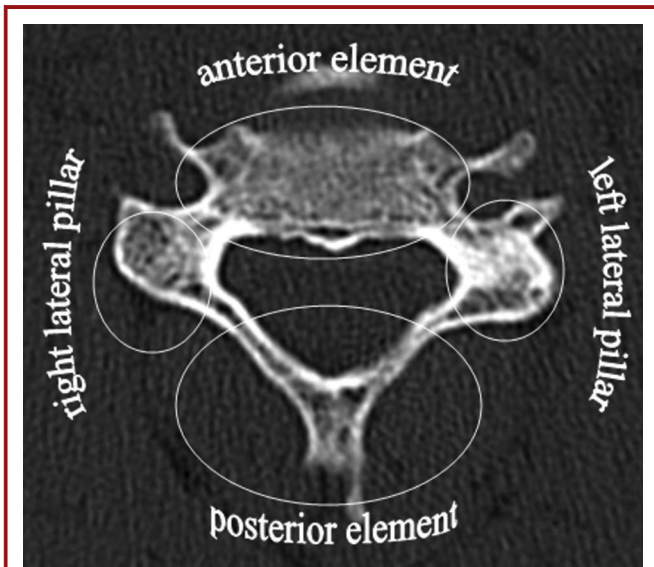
Axial reformatted CT scan of the cervical spine depicting the 4-anatomical pillar concept of Anderson Classification.
